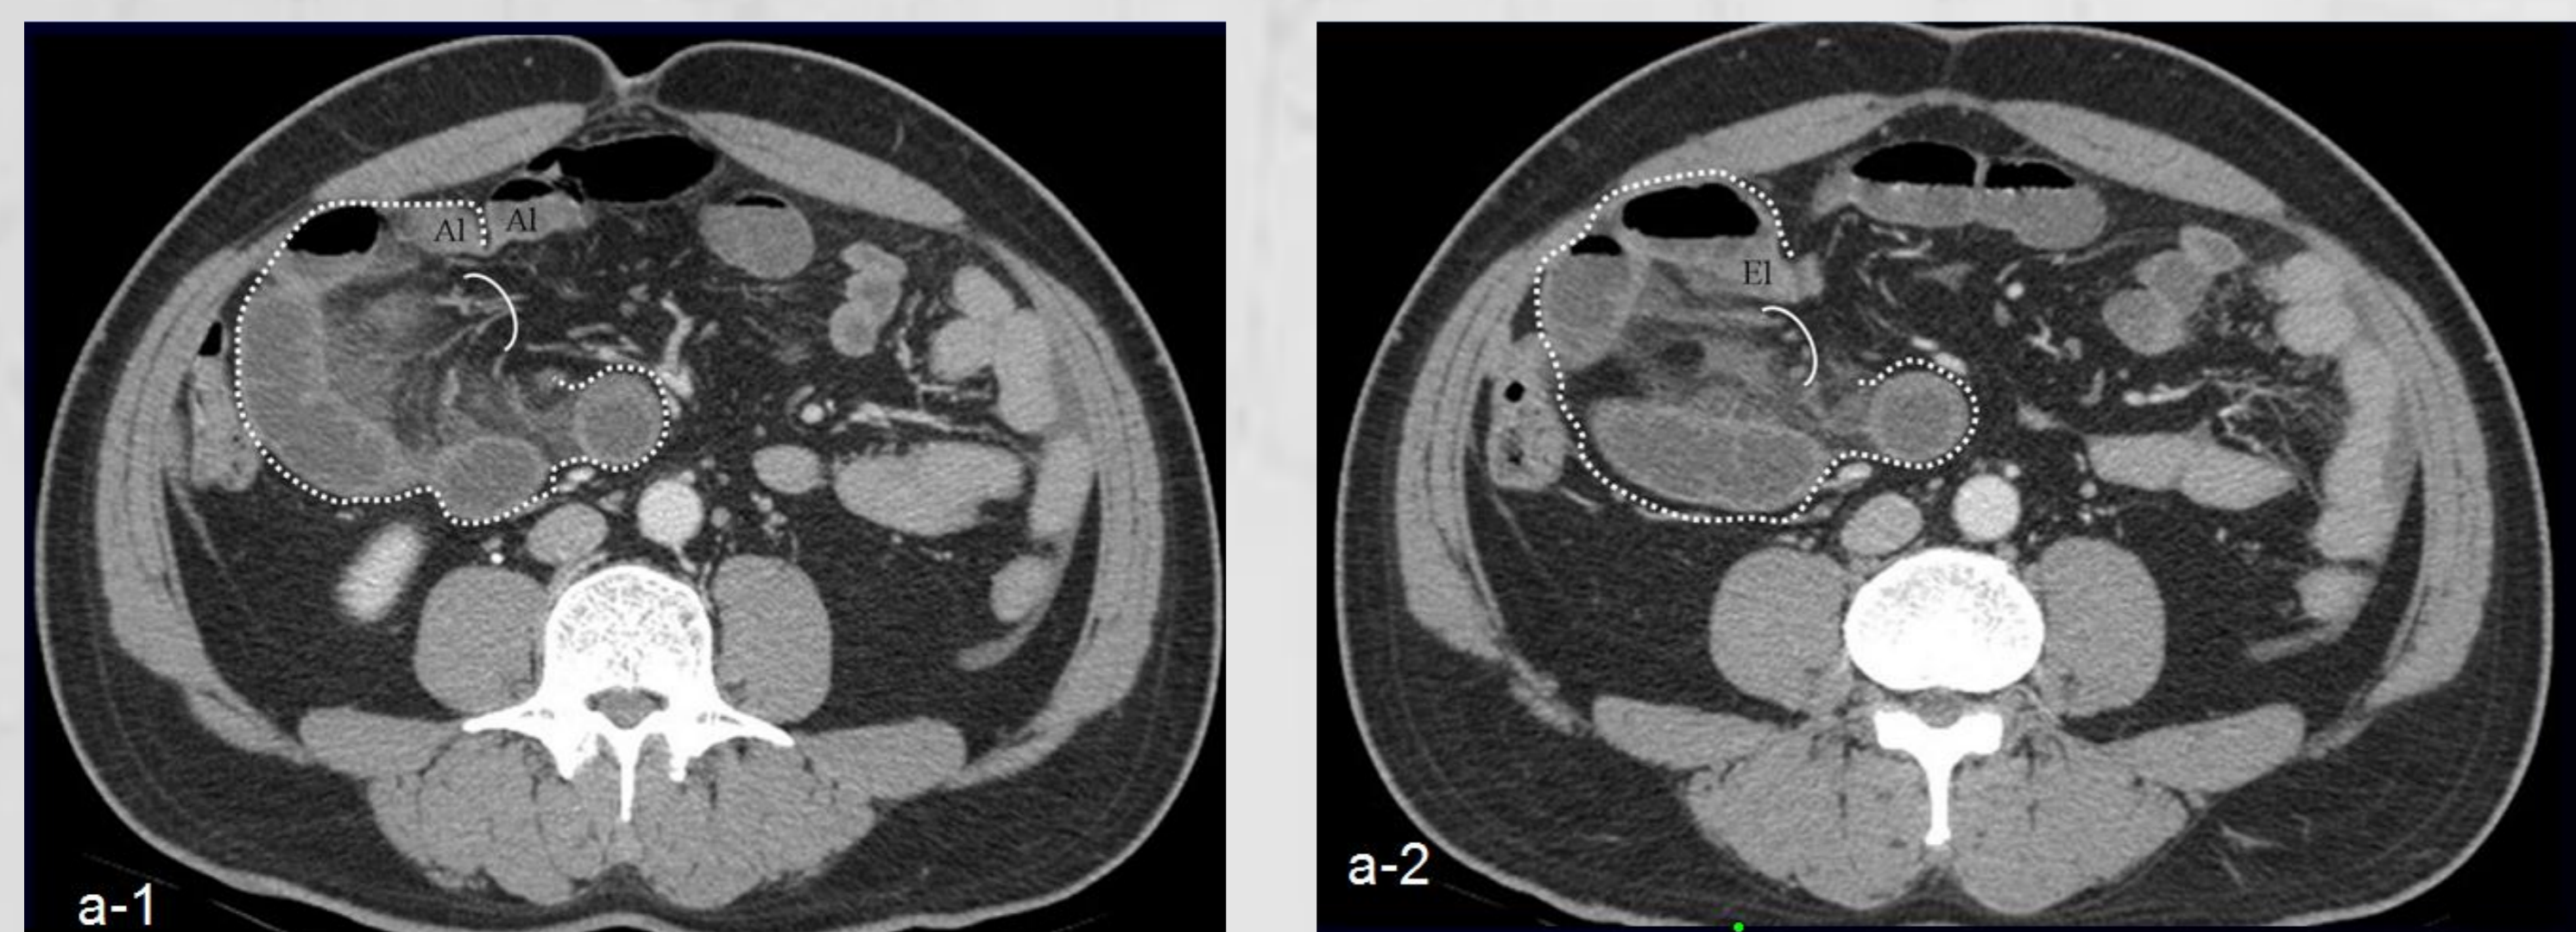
Axial (a-1, a-2), coronal (a-3) CT revealed cluster of small bowel loops (dotted line) transited through mesenteric defect (curve line). Note the closely apposed afferent (AI), efferent (EI) loops and accompany vessels also transited through mesenteric defect.
